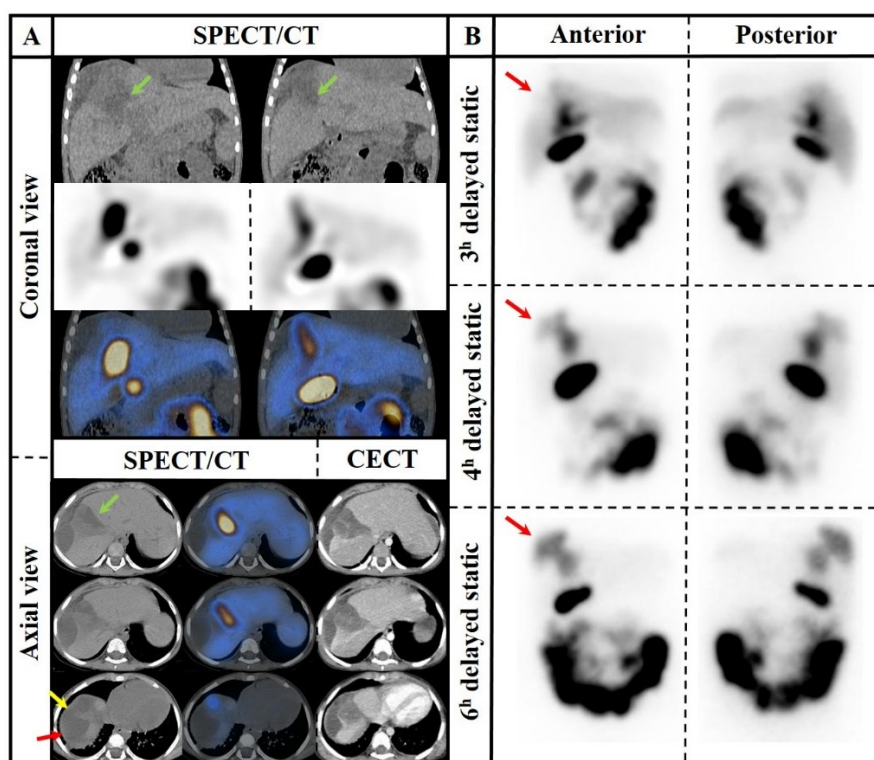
(Panel A) Fused SPECT/CT images correlated with contrast-enhanced CT demonstrate a hypodense lesion in segment V of the liver with radiotracer uptake on the SPECT component, suggestive of a ruptured or dilated biliary tract (green arrows). A larger hypodense area in segment VIII shows no tracer activity (red arrows), suggesting either a hematoma or an inactive bile leak. In superior slices, continuity between the two hypodense regions is observed (yellow arrow), supporting the diagnosis of a biloma involving the entire lesion. (Panel B) Delayed static images acquired up to six hours post-injection reveal progressive tracer accumulation within the previously photopenic area in segment VIII (red arrows), confirming the presence of an active bile leak
